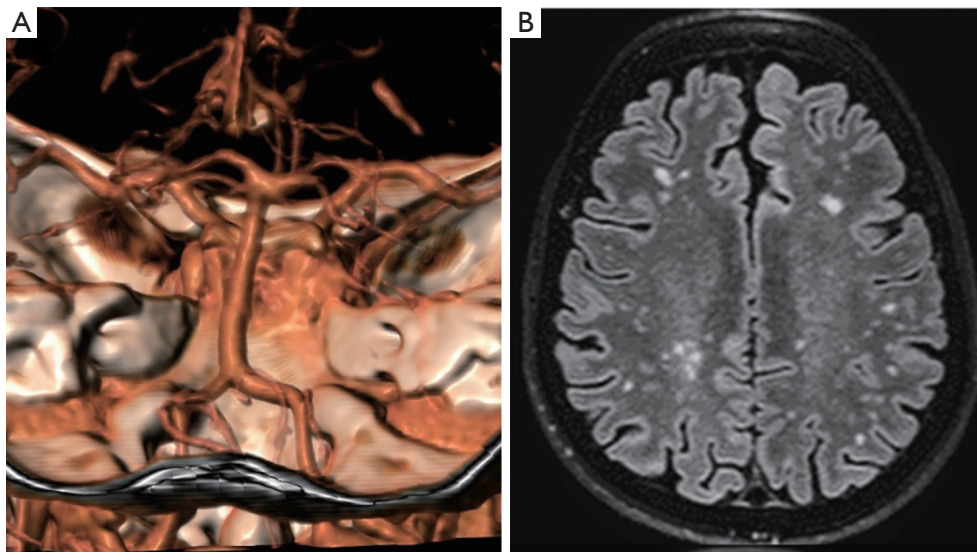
Brain imaging in LOPD. (A) CT-scan showing a vertebral dolichoectasia in a 64-year-old LOPD female; (B) T2 weighted scan showing a lacunar encephalopathy (Fazekas score 2). LOPD, late onset Pompe disease.
